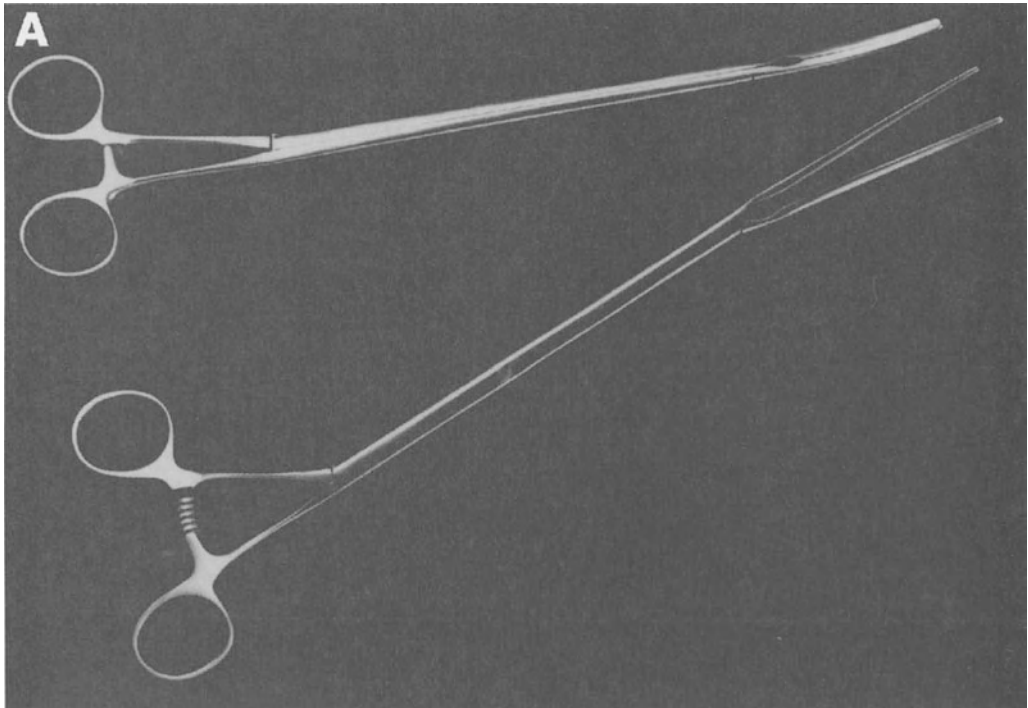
Instruments: Custom instruments designed for the video-assisted MMO. (A) The transthoracic aortic cross clamp is shown in two “pincer tip” lengths. The sliding mechanism precludes wound impingement. (B) Specially designed forceps and knot-tier used for the MMO. Note the specialized diamond platform-tipped forceps used for (*left to right*): needle retrieval, delicate tissue manipulation, thickened valve tissue, and knot-tying/valve prosthesis seating (Scanlan International, Minneapolis, MN).
